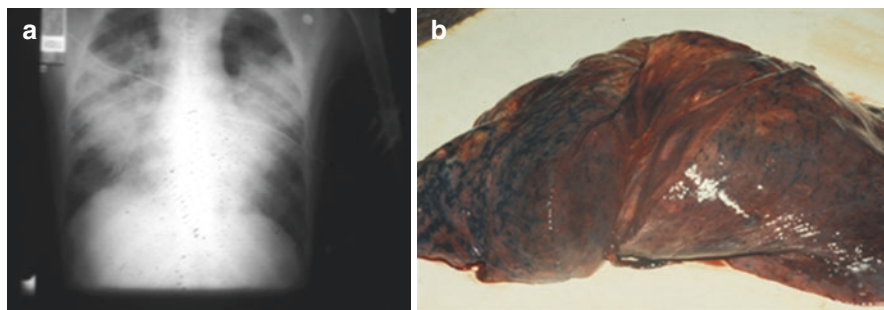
Typical X-ray (a) of severe blast lung injury showing typical bilateral patchy lung infiltrates (“butterfly” pattern). Macroscopic picture of blast lung from patient injures inside the bus (b). Severe edema and parenchymal hemorrhage are seen. Reprinted with permission from Almogly G, Rivkind AI. *Terror in the 21st century: milestones and prospects--part I.* *Curr Probl Surg.* 2007;44:496–554. Copyright Elsevier 2018
